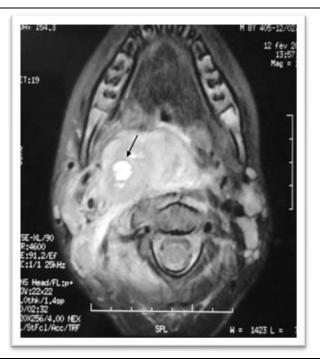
MRI scan showing a peri tonsillar abscess with surrounding soft tissue inflammation causing partial obstruction of oropharynx
